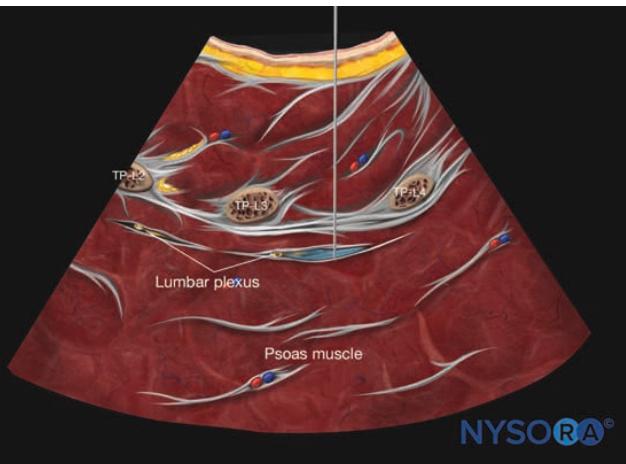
Reverse ultrasound anatomy of a lumbar plexus block in a sagittal approach with the needle inserted out-of-plane.
